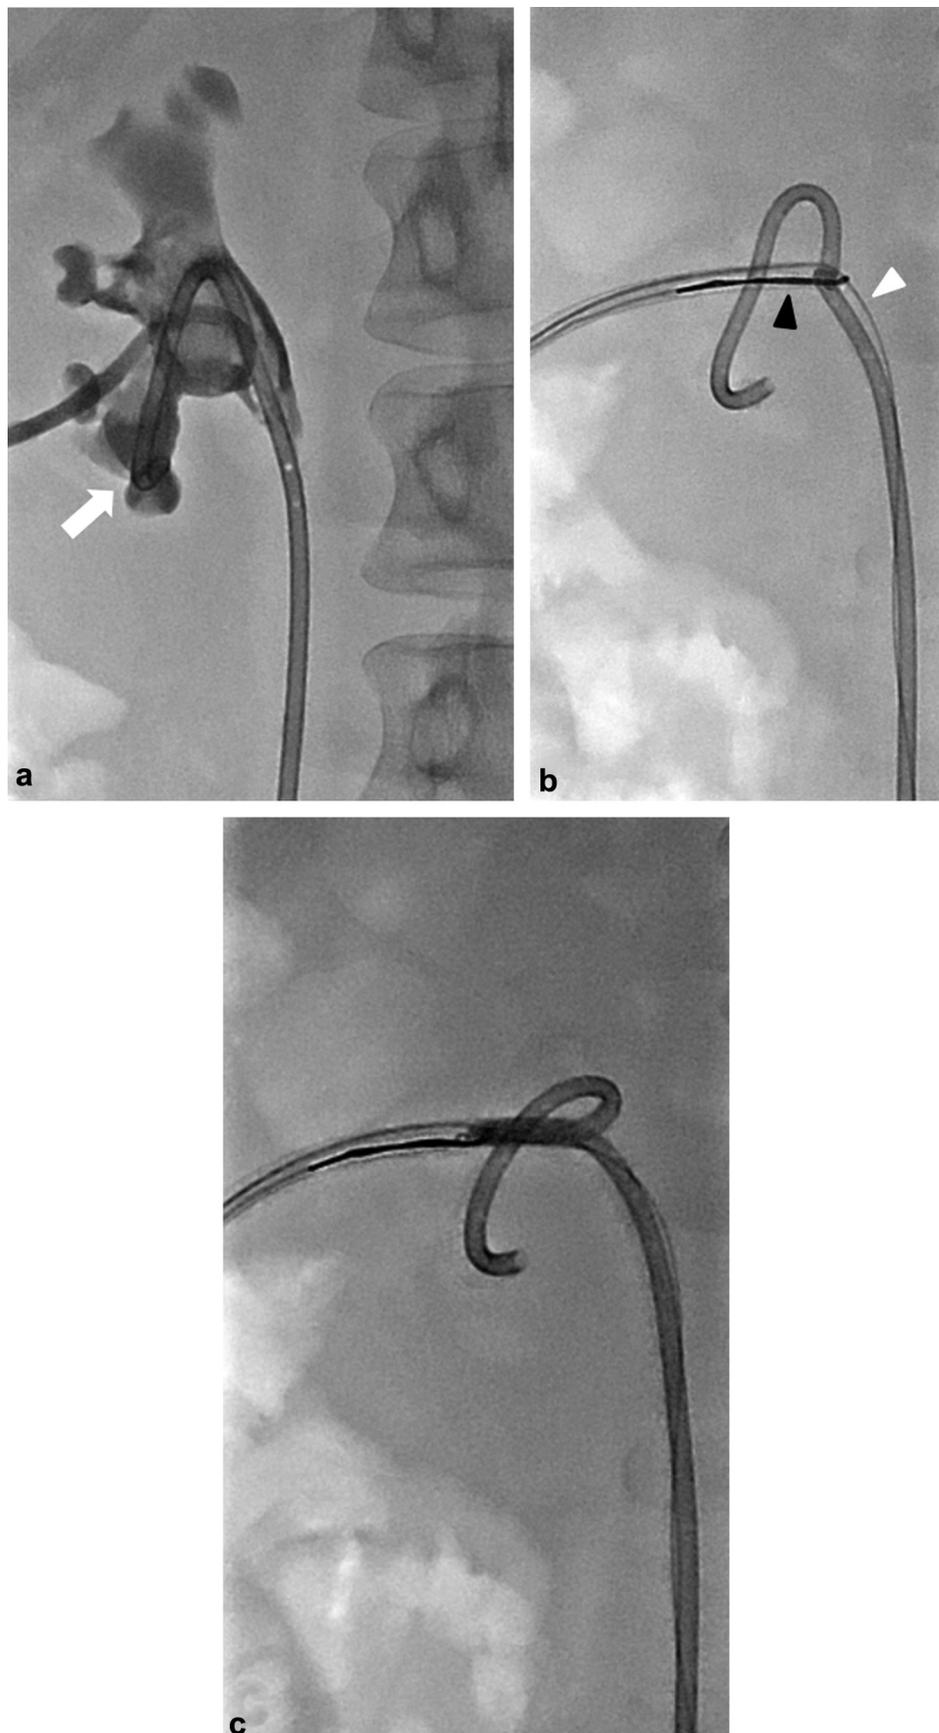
The modified snare technique in a 34-year-old woman. (a) Scout radiograph obtained after a contrast medium injection shows the embedded proximal DJ stent tip (arrow) in the lower renal calyx. The stent could not be removed using the simple snare technique. (b) After an additional guidewire (white arrowhead) was inserted through the vascular sheath, the combination of the snare (black arrowhead) and guidewire was able to capture the DJ stent. (c) The entire assemblies, including the DJ stent, guidewire, and snare, were pulled to remove the DJ stent.
